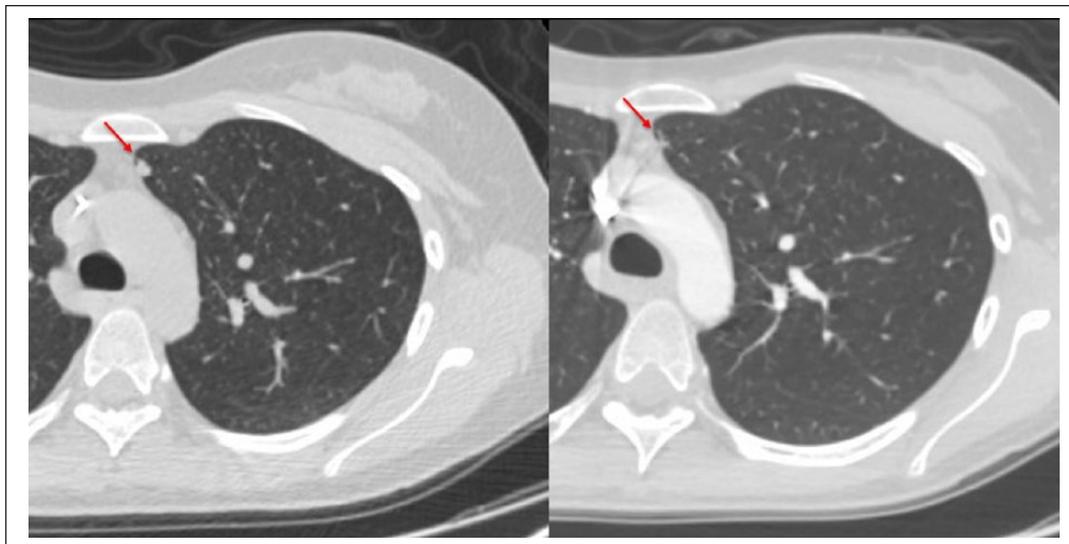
CT scan of the lungs showing reduction in the size of a left lung nodule.
